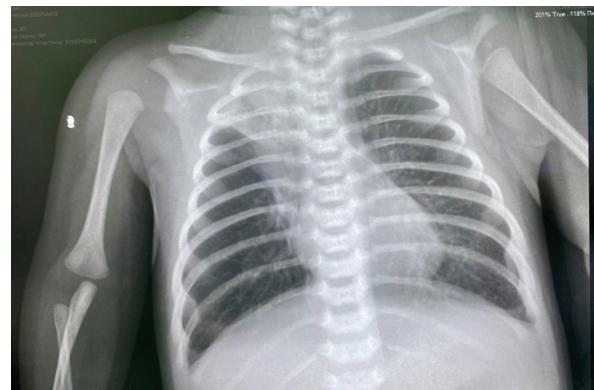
X-ray of the lungs in dynamics; atelectasis of the right upper lobe.
